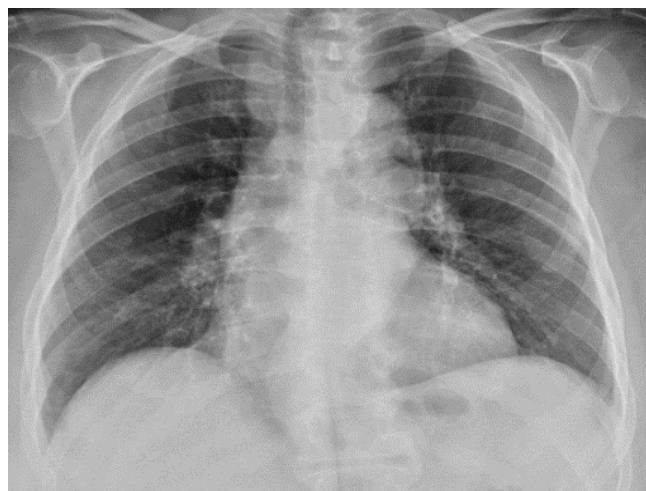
Chest X-ray after treatment
